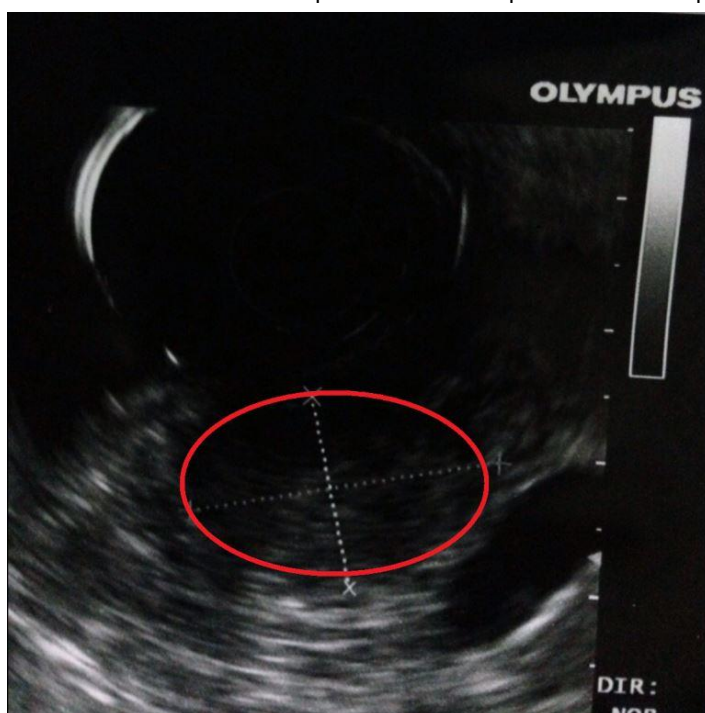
Endoscopic ultrasonography shows a well-demarcated oval hypo-echoic mass, 24 x 15 mm in maximum diameters (within the red circle), adjacent to the portal vein confluence. The mass is clearly separated from the vessel.
